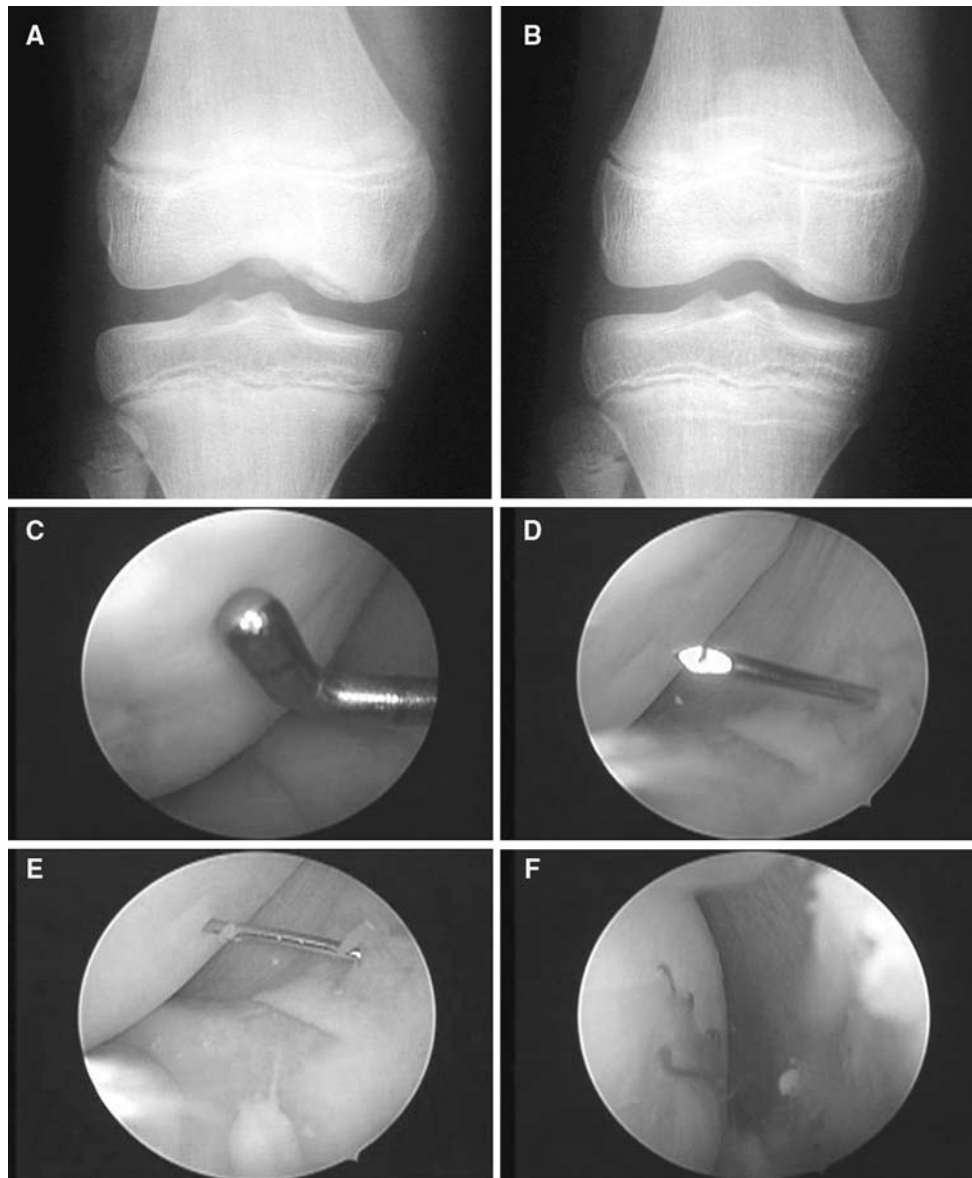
a Grade II b Bedouelle OCD. b Radiograph 6 months later with a Hughston radiological score of 4. c Arthroscopic views for the same patient. Localization of the OCD region. d, e Transchondral drilling with a 1.2-mm K-wire. f Bleeding from the drilling holes
